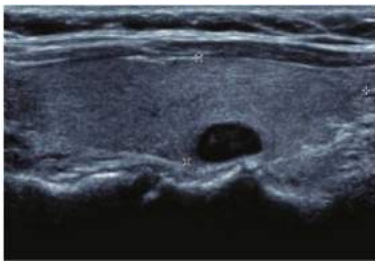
• Ultrasound (same patient in FIG 3). Right parathyroid adenoma posterior to the middle third of the thyroid lobe: right superior parathyroid adenoma in location 1. EPLA is indicated.
